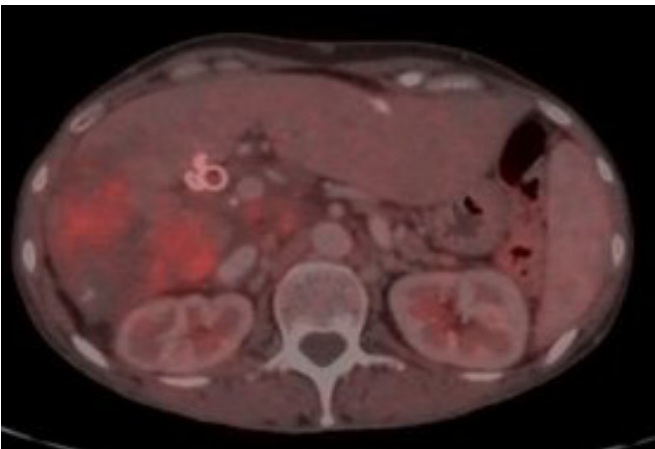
Description of the Figure: POST-TX PET-CT
